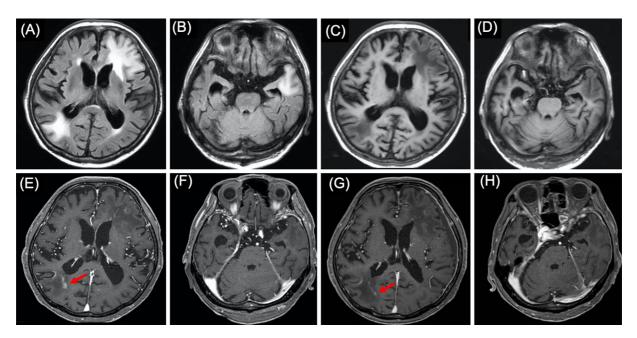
Brain magnetic resonance images showing subcortical white matter lesions of the right parietal lobe and the left frontotemporal lobe. Axial (A, B) T2-weighted fluid attenuated inversion recovery, (C, D) T1-weighted, and (E, F) gadolinium-enhanced T1-weighted images of the brain at admission. Arrows show T1-hypointense lesions with patchy gadolinium enhancement. (G, H) Axial gadolinium-enhanced T1-weighted images of the brain at 14 days after treatment.
